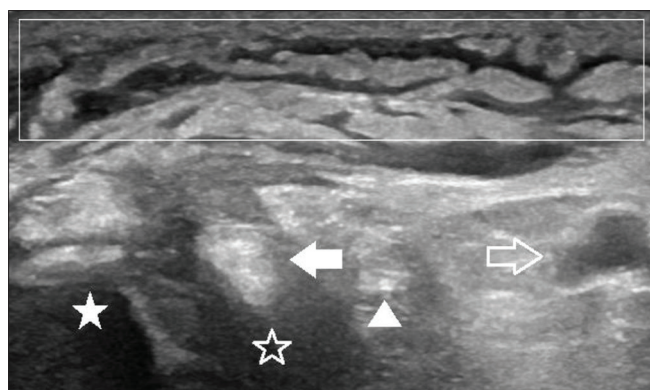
Sonographic findings of medial ankle subcutaneous edema and posterior tibial tenosynovitis in a 48-year-old woman with severe left medial ankle pain. Short-axis ultrasound image demonstrates increased echogenicity of the subcutaneous fat with interposed curvilinear hypoechoogenicity corresponding with fluid and consistent with severe subcutaneous edema (empty rectangle). The empty rectangle also depicts the area cropped for the radiologist image review. The posterior tibial tendon (solid arrow) is also seen adjacent to the medial malleolus (solid star). Posterior tibial tenosynovitis is manifest by complex hypoechoogenicity in the tendon sheath (empty star), circumferentially surrounding the tendon. The flexor digitorum longus tendon (triangle) and posterior tibial artery and paired veins are also present (empty arrow)
